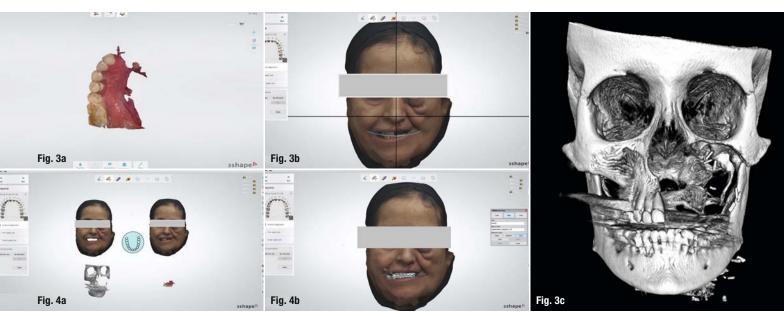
Intra-oral digital impression of the right maxilla. Fig. 3b: 3D facial scan. Fig. 3c: CBCT image. Fig. 4a: Acquired 3D data placed into one software program: facial, CBCT and intra-oral scan data. Fig. 4b: Merged digital data using the Dental System software.
